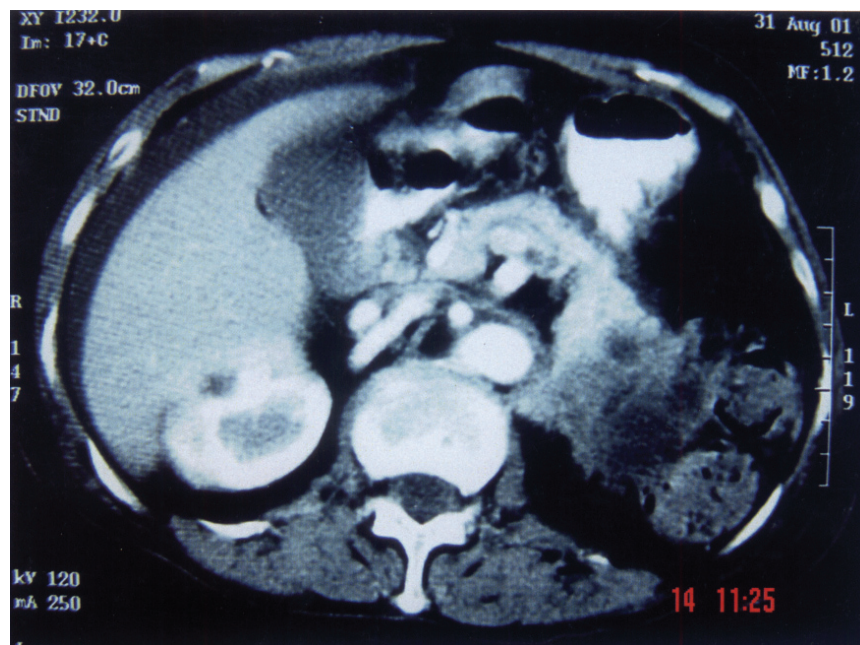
Abdominal CT scan with IV contrast (cystic lesion with solid components in the pancreatic body).
